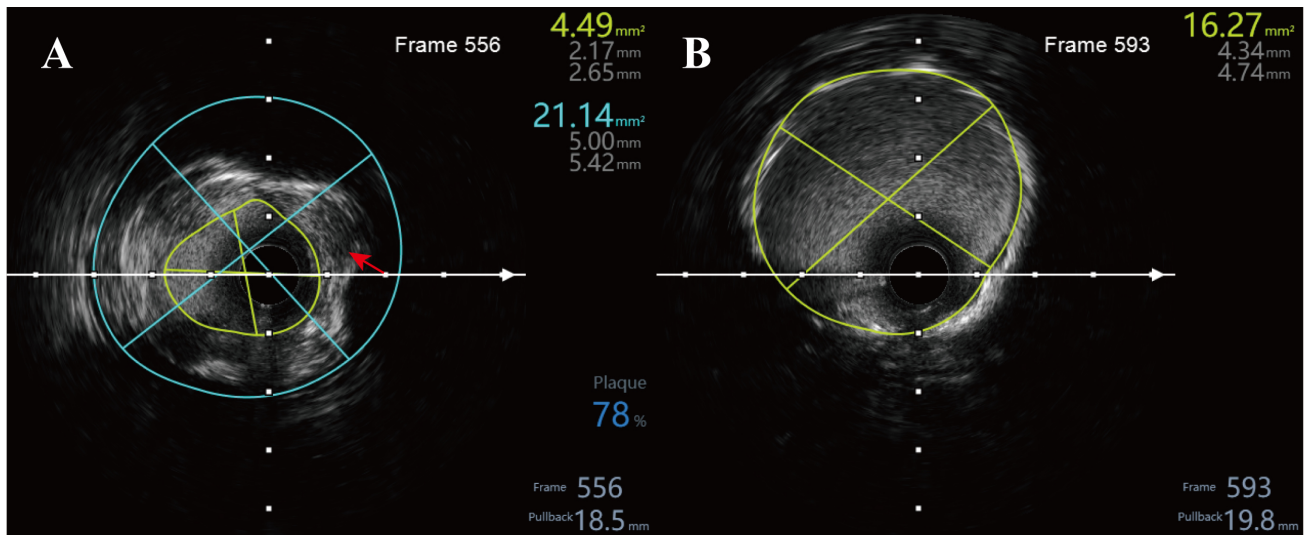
Intravascular ultrasound (IVUS) assessment. (A) After balloon predilation at the culprit right coronary artery (RCA) stenosis, IVUS shows a minimal lumen area (MLA) of 4.49 mm² (minimum/maximum lumen diameters 2.17/2.65 mm) and an external elastic membrane (EEM) area of 21.14 mm², corresponding to an estimated plaque burden \approx 78%; the red arrow indicates a coronary dissection with intramural hematoma. (B) Following drug-eluting stent implantation and optimization, IVUS demonstrates a minimal stent area (MSA) of 16.27 mm² (minimum/maximum stent diameters 4.34/4.74 mm) with good expansion and apposition and no edge dissection.
